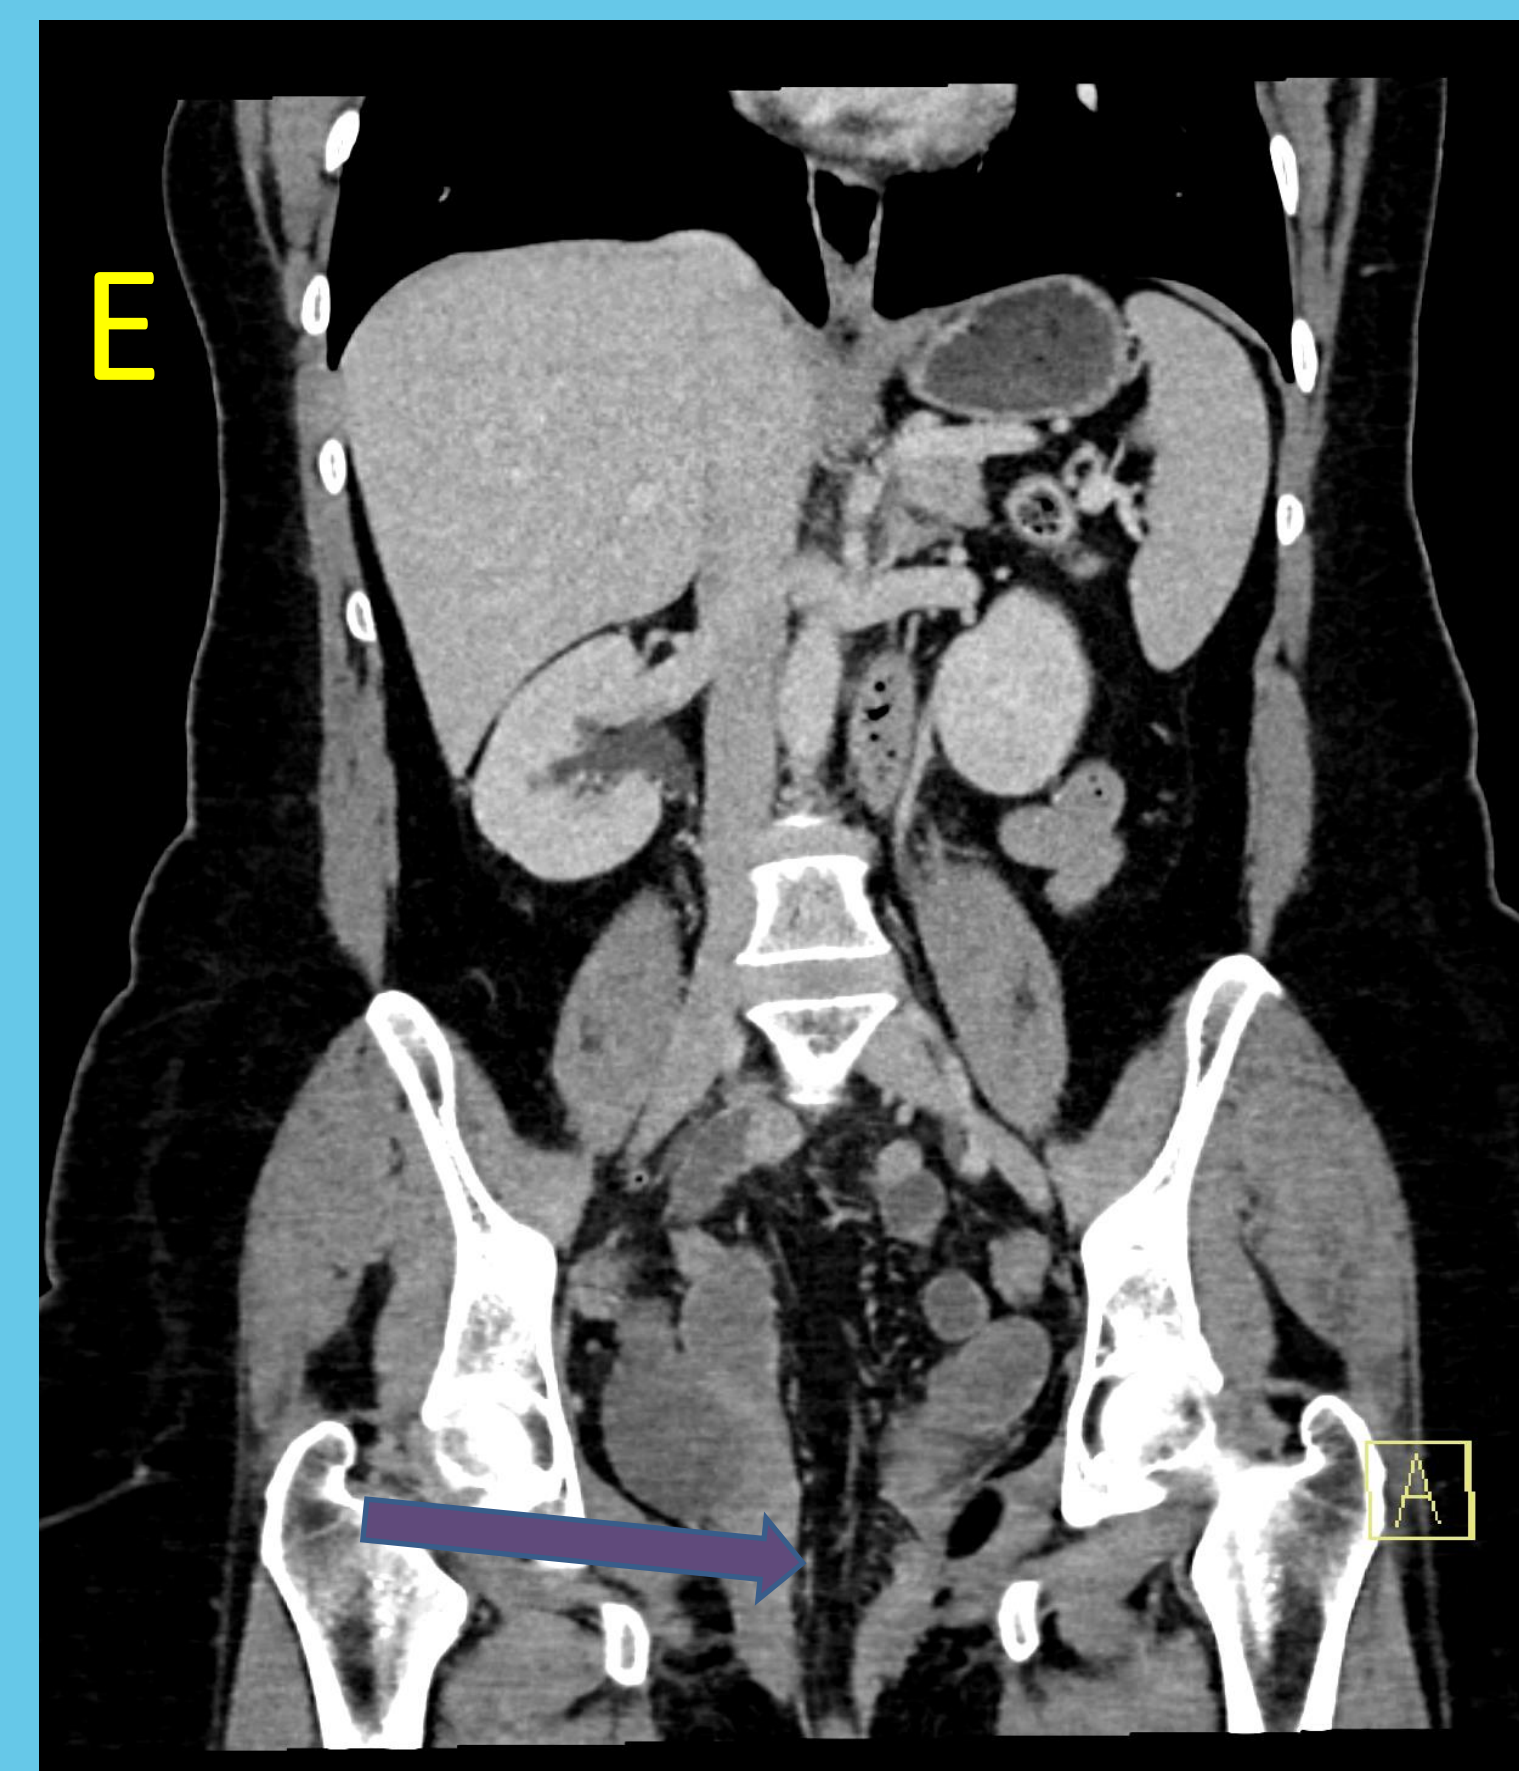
Coronal image CT Abdomen and Pelvis with a purple arrow pointing to the mesenteric fat prolapsing into the pelvis, that could be further localized to the vaginal cuff on the axial images as above
